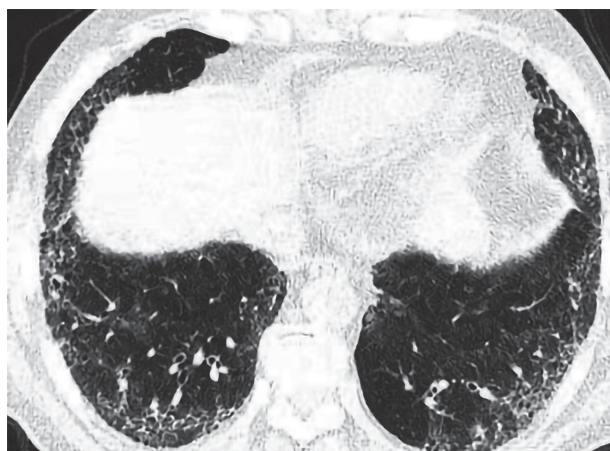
The post-treatment chest HRCT shows fine reticular shadows around both lower lungs, accompanied by honeycombing.
